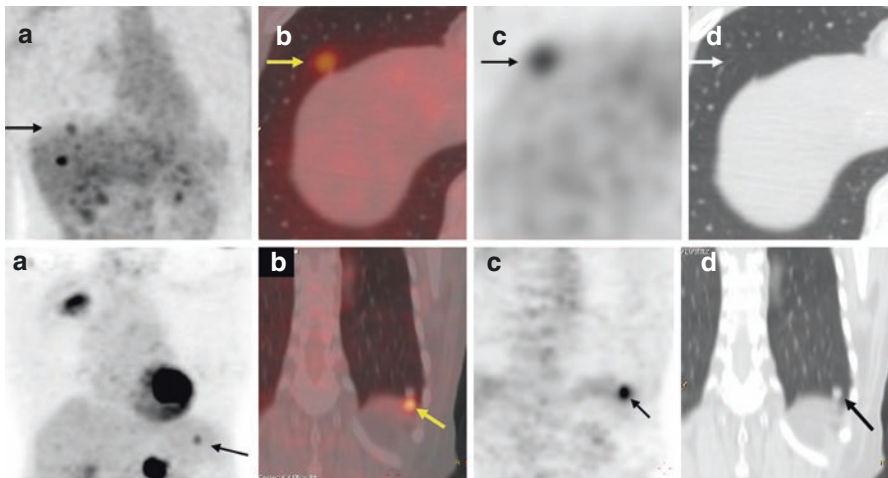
(i) (a) MIP (maximum intensity projection) of FDG PET/CT scan artifactually shows the hypermetabolic liver lesions in the right lower thorax (arrow) due to respiratory artifact. (b, c) Axial fused PET/CT and PET images show a hypermetabolic focus in the base of the right lung (arrow). No corresponding lesion is noted in the lung in the axial CT image (d). (ii) (a) MIP image of FDG PET/CT artifactually shows a hypermetabolic lesion in the spleen (arrow) due to respiratory artifact. (b, c) Coronal fused PET/CT and PET images show a hypermetabolic focus in the spleen (arrow). (d) Coronal CT image clearly shows a nodule in the base of the left lung (arrow) which is artifactually seen as a hypermetabolic focus in the spleen in image b, c. This occurs due to acquisition of PET and CT data during different phases of respiration
